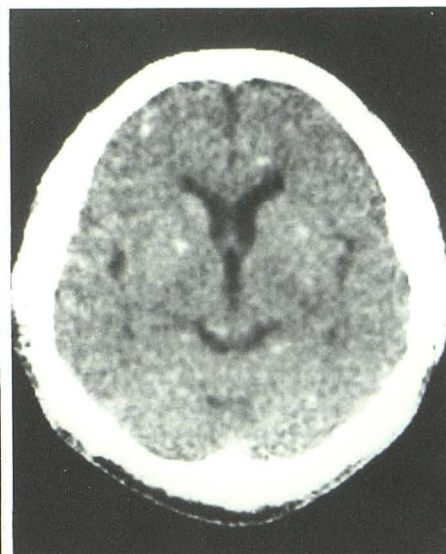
CT-suggestive but ELISA-positive case with hydrocephalus only on CT. This case was surgically proved to have cysticercosis in fourth ventricle.
